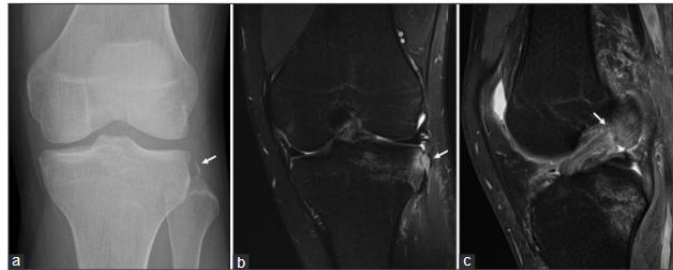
AP radiograph (a) of knee showing fracture of the lateral part of the lateral tibial condyle (arrow). Coronal (b) and sagittal (c) MRI scans showing the fracture (arrow) with tear of ACL (arrow). PDFS: Proton density fat saturated, ACL: Anterior cruciate ligament, AP: Anteroposterior (Bonab *et al.*, 2023)
